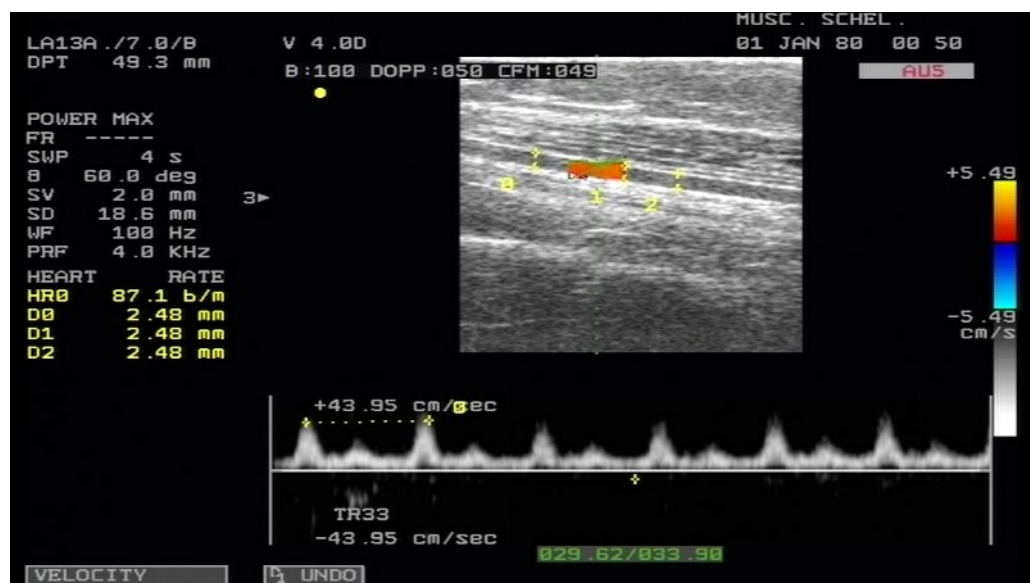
Ultrasound set-up and screen grab of arterial resting blood flow.
